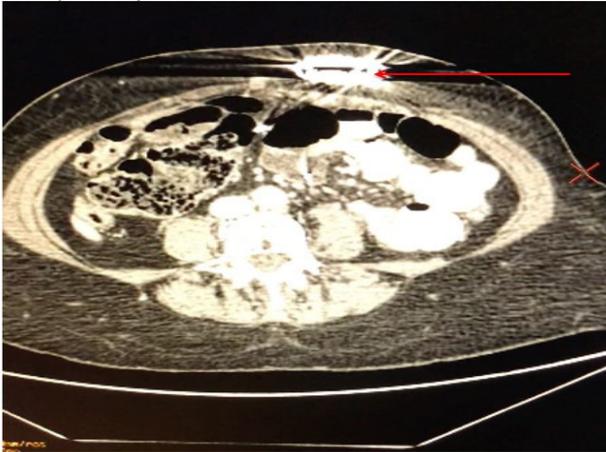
Axial CT scan showing the subcutaneous pacemaker
